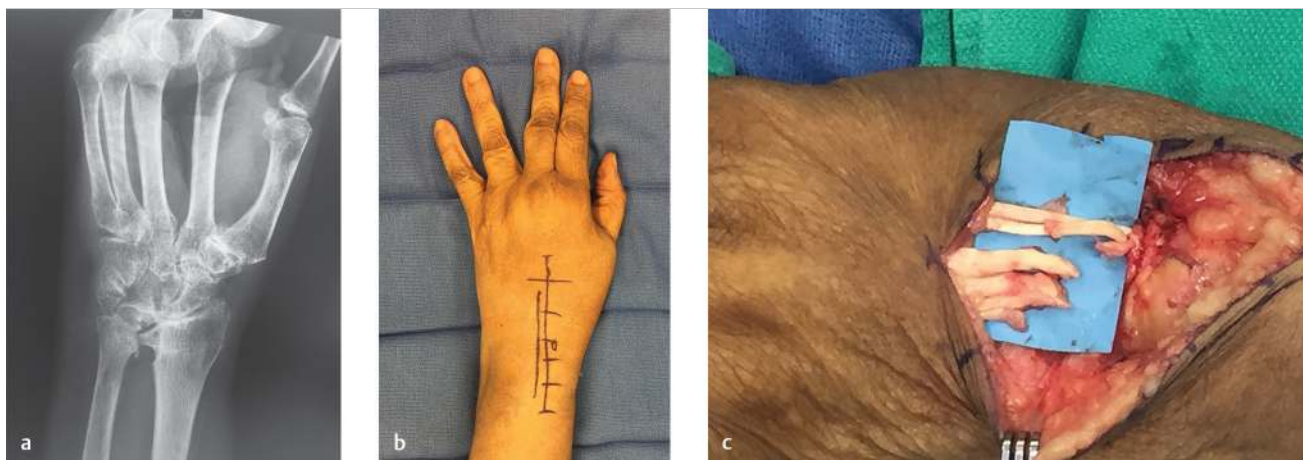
Vaughan-Jackson syndrome. Inability to extend fingers due to rupture of digital extensor tendons from ulnar to radial sided fashion. Results from distal radioulnar joint (DRUJ) instability with dorsal ulnar head creating friction point for extensor tendon glide, eventually causing rupture. (a) Radiograph of rheumatoid arthritis patient showing erosions, carpal space narrowing, ankylosis, and DRUJ involvement. (b) This patient had inability to extend small, ring, and long fingers. Scheduled to undergo extensor reconstruction and Darrach's procedure (ulnar head resection). (c) Intraoperative photo of same the patient demonstrating all extensor tendons ruptured except extensor indicis proprius (EIP) and extensor digitorum communis (EDC) to index finger. These tendons were used to reconstruct the other extensor defects.
